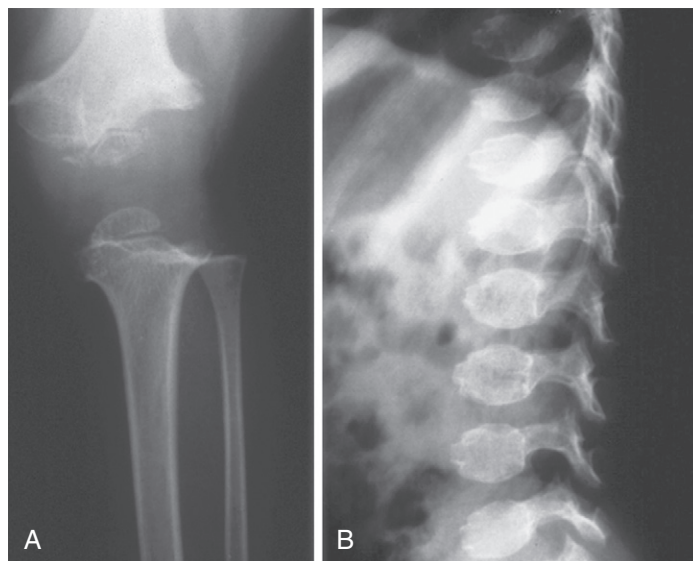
Radiographs showing abnormalities in the chondrodysplasias, specifically pseudoachondroplasia. A, Irregular metaphyses and small epiphyses. B, Small, rounded vertebrae with anterior beaking.
